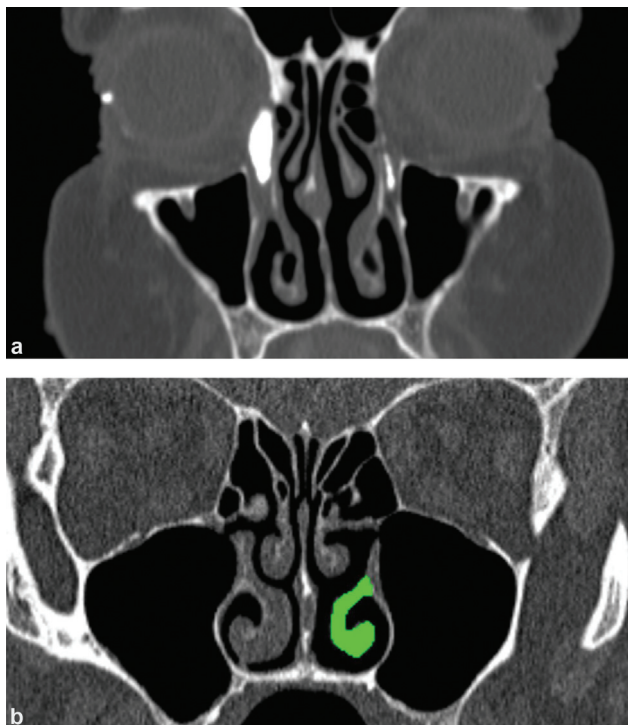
Computed tomography results in a patient with SALDO (a) and PANDO (b) during inferior nasal concha volume measurement.
